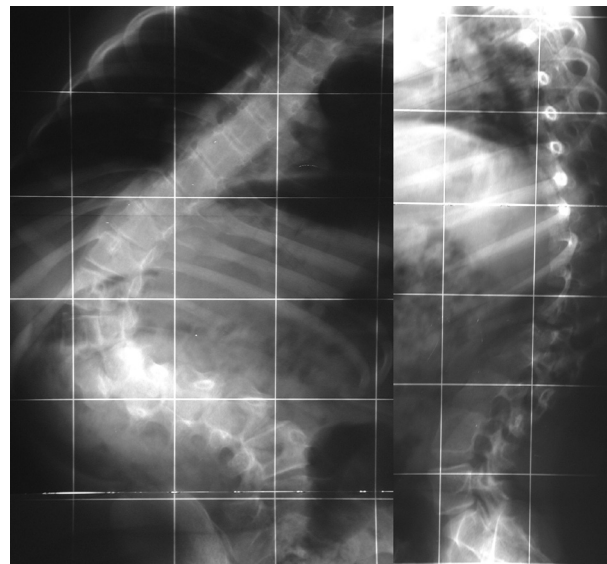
The anterior-posterior and lateral preoperative x-rays show a right convex thoracolumbar scoliosis and Cobb angle of 115 degrees (Th8-L3) with a left convex lumbar Cobb angle of 52 degrees. In the lateral view, a hyperkyphosis of 48 degrees appears between Th4 and Th12.
